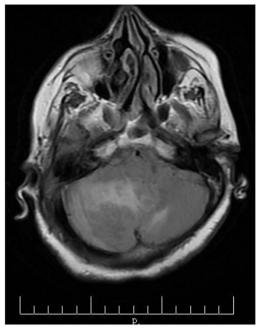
Fluid-attenuated inversion-recovery (FLAIR) image. The mass remained heterojen hyperintense.
